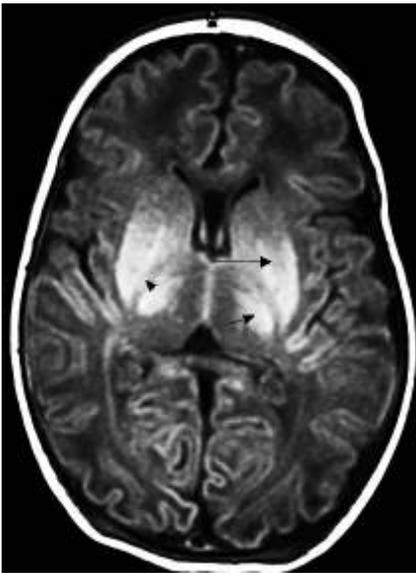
T1-weighted MR image at the level of the basal ganglia shows symmetrical high signal in the posterior putamina (long arrow), thalami (short arrow), and posterior limb of the internal capsules (arrow head) in an infant born at 37 weeks 5 days of gestation with severe perinatal asphyxia due to intertwined umbilical cord. Imaging was performed 6 days after birth at a post-conceptual age of 38 weeks 4 days.
